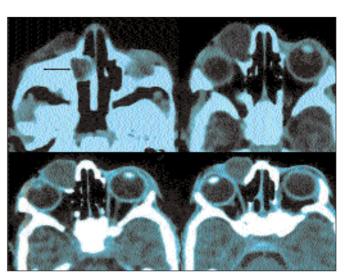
Axial computed tomography scan shows enlargement of the right lachrymal sac with an intranasal cyst (black arrow).
